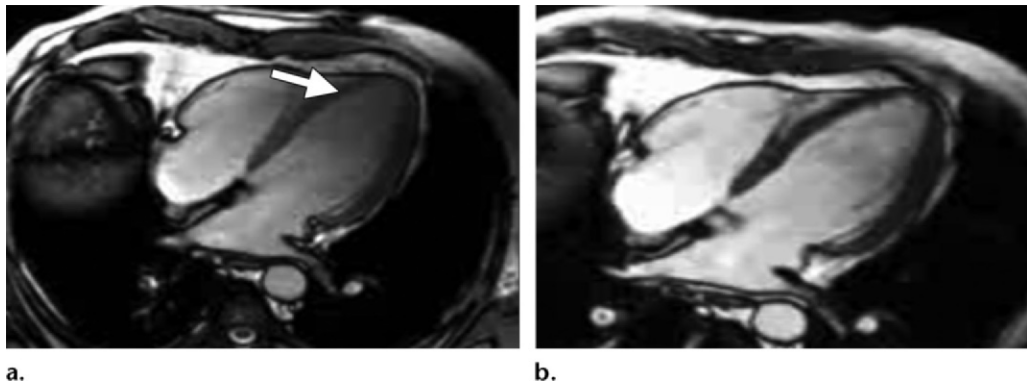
B_1 inhomogeneities and shading. (a) Four-chamber SSFP MR image shows heterogeneous loss of signal intensity in the apical regions of the cardiac chambers (arrow) because of B_1 inhomogeneities inherent at 3 T. (b) Four-chamber SSFP MR image at the same location shows that the addition of a radiofrequency multitransmit coil improves the appearance of dielectric shading.
